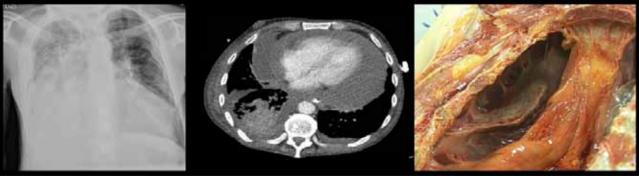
Chest X-ray (left), CT-scan (middle) and autopsy of the thorax (right). Chest X-ray thorax: cardiomegalia; consolidation of the right lung and pleural effusion. CT-scan: consolidation and pleural effusion of the RLL and pericardial effusion. Autopsy of the thorax with extensive pleural adhesions in the right hemithorax and consolidation of the right lung.
